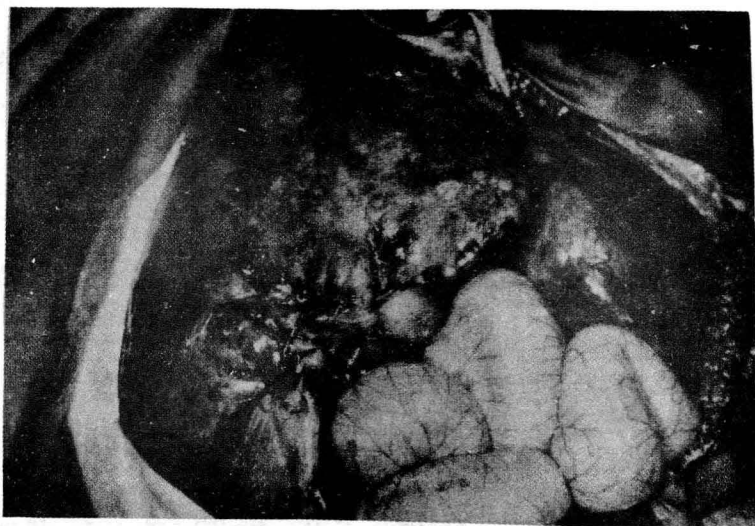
Markedly enlarged liver of an infant with neuroblastoma showing numerous focal metastases. X-ray therapy and chemotherapy resulted in prolonged survival. (Courtesy of Dr. Martin Winnick)
